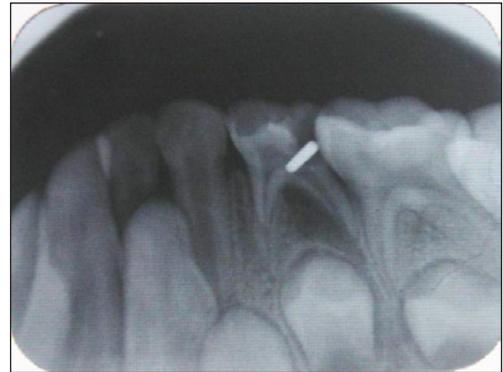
Intraoral periapical radiograph of a primary mandibular left first molar with a radiopaque pin-like foreign body lodged in the pulp chamber.
